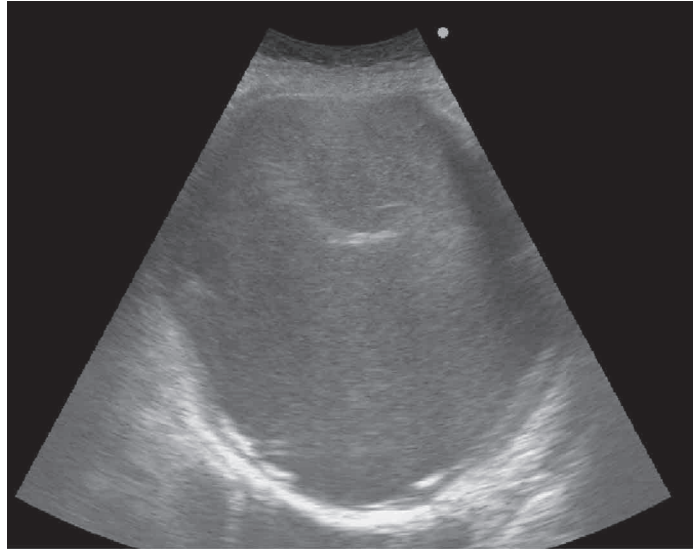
Abdominal ultrasonography revealed a huge cystic tumor sized 20 cm with wall calcifications in the hilus of the spleen. The spleen was compressed by the cyst which was markedly swollen but the splenic vein seemed intact.
